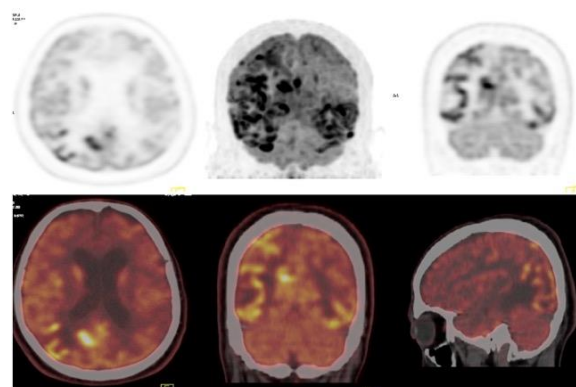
Hybrid ¹⁸F-FDG PET/CT images demonstrating generalized heterogeneous increased ¹⁸F-FDG uptake in the right hemisphere and left temporal lobe as well as decreased ¹⁸F-FDG uptake in the left fronto-parietal lobe.
